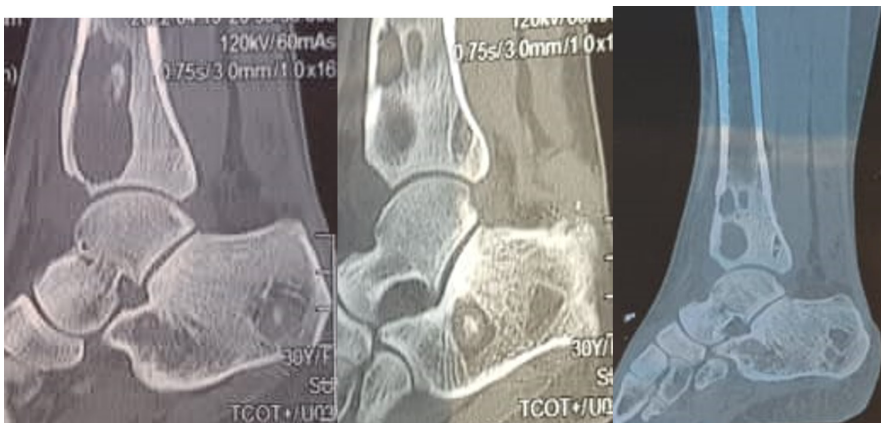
Pretreatment CT scans of the ankle and foot (sagittal bone window) showed multiple intraosseous cystic lesions with sclerotic, well-defined margins with narrow zone of transition in tibia, calcaneum, talus and many tarsal bones.
